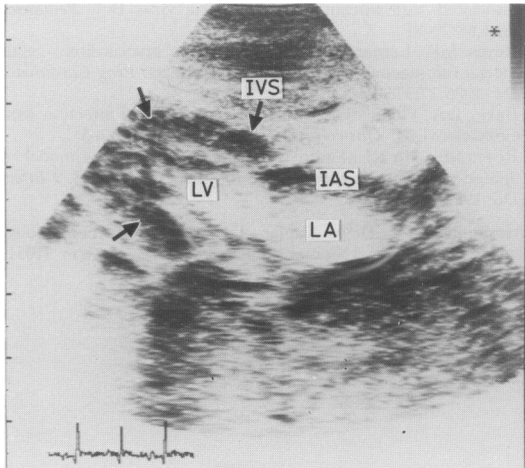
Echocardiogram (subxiphoid four chamber view) at age 4 months. Note areas of extreme echogenicity in the left ventricular myocardium (arrows) probably due to calcification. IVS: interventricular septum; IAS: interatrial septum; LV: left ventricle; and LA: left atrium.
